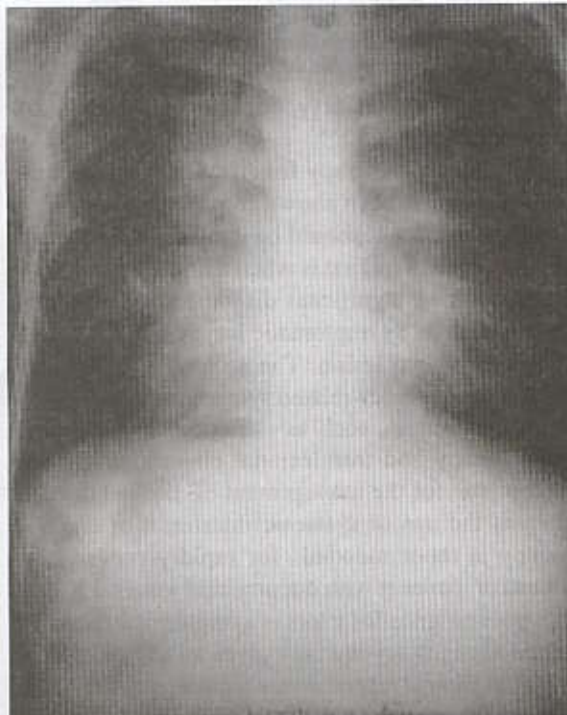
Chest radiography showed bilateral hilar nodes enlargement with diffuse patchy nodular infiltration.
